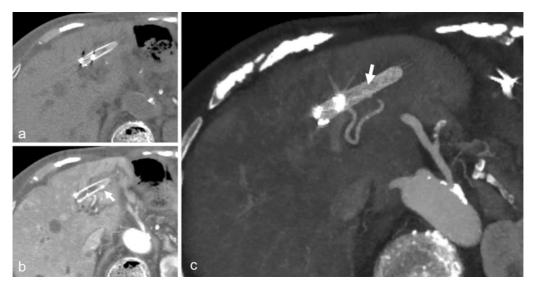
By comparing non-contrast CT (a) with CECT (b), it is possible to identify a pseudoaneurysm that exists along the bile duct stent. The slab maximum intensity projection (c) suggests continuity between the pseudoaneurysm (arrow) and the left hepatic artery.
